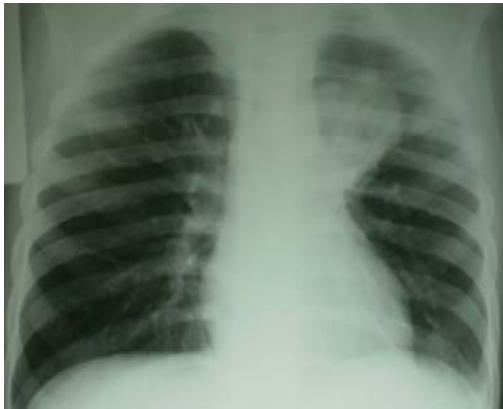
Chest radiography 11.12.2013*
